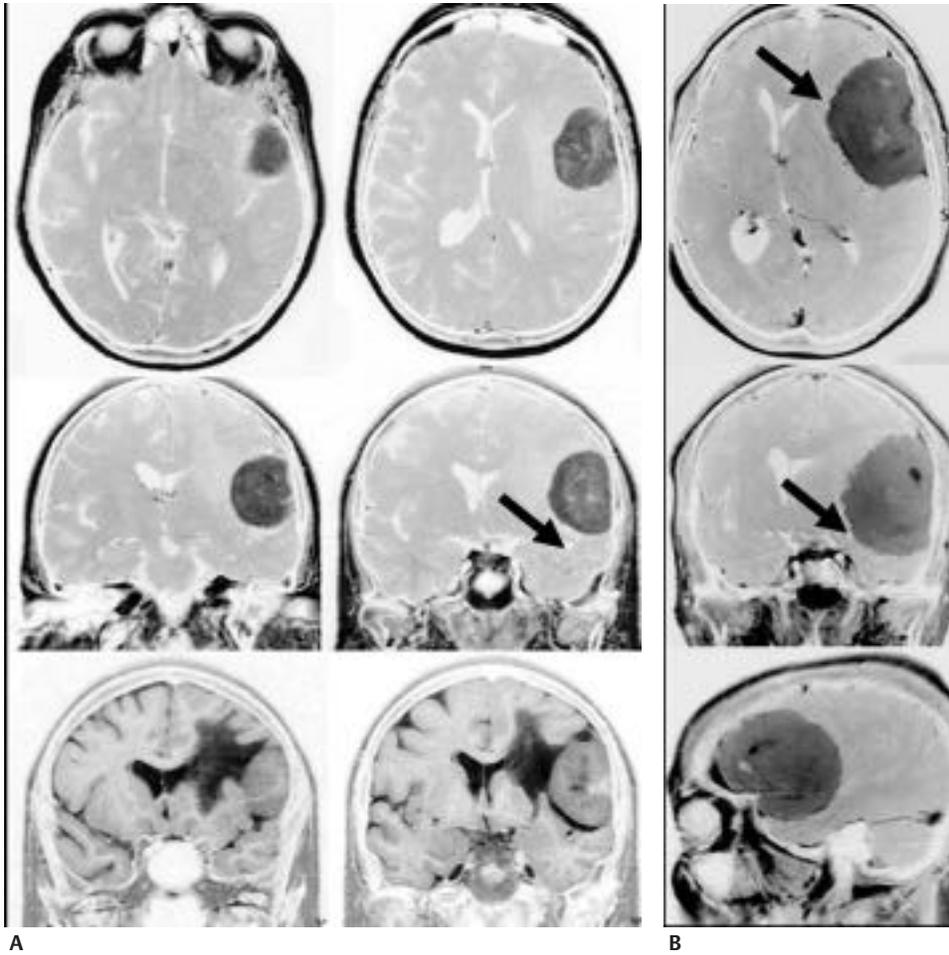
Two lateral sphenoid wing (pterional) meningiomas. (A) Medium-sized meningioma originating from the most lateral aspect of the left greater sphenoid wing (T1-weighted contrast-enhanced axial and coronal, and T2-weighted coronal scans). Surgery for this tumor was no different from surgery for a convexity meningioma. The middle cerebral artery (*arrow*) was protected by a thin layer of brain tissue, and identification and preservation of its distal branches were not difficult. (B) A much larger tumor in a similar location diagnosed in a 67-year-old female patient who presented with flattened affect, cognitive decline, a possible seizure, and a mild hemiparesis (triplanar T1-weighted contrast-enhanced scans). The middle cerebral artery (*arrow*) proved relatively easy to dissect; however, several M3 branches were engulfed by the tumor. Copyright M. Simon and J. Schramm, reproduced with permission
